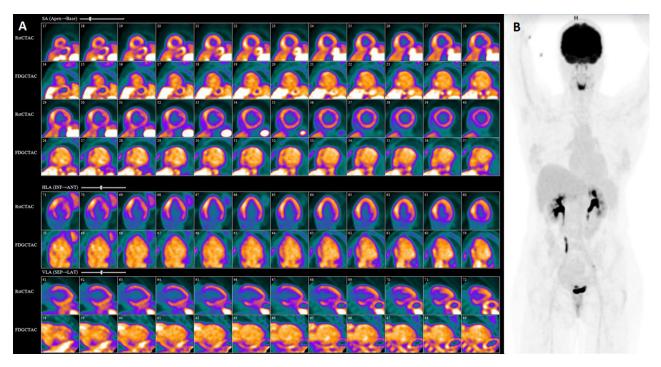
Cardiac PET F18-FDG showing lack of F18-FDG uptake by the myocardium suggesting absence of active inflammation (A resting Rb-82 perfusion and F18-FDG images which show myocardial blood pool signal; B time-of-flight images with no increased myocardial F18-FDG signal).
